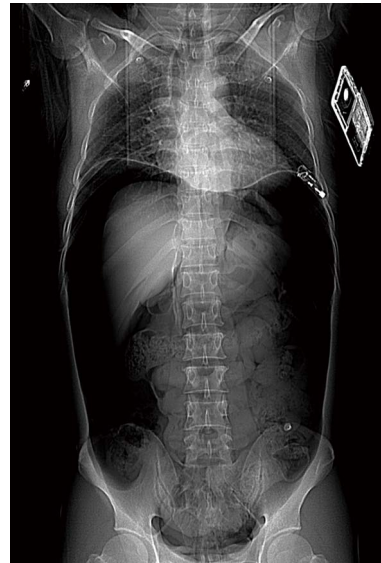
X-rays taken in the supine position, showing a large volume of air in the abdominal cavity, and elevated diaphragm.
